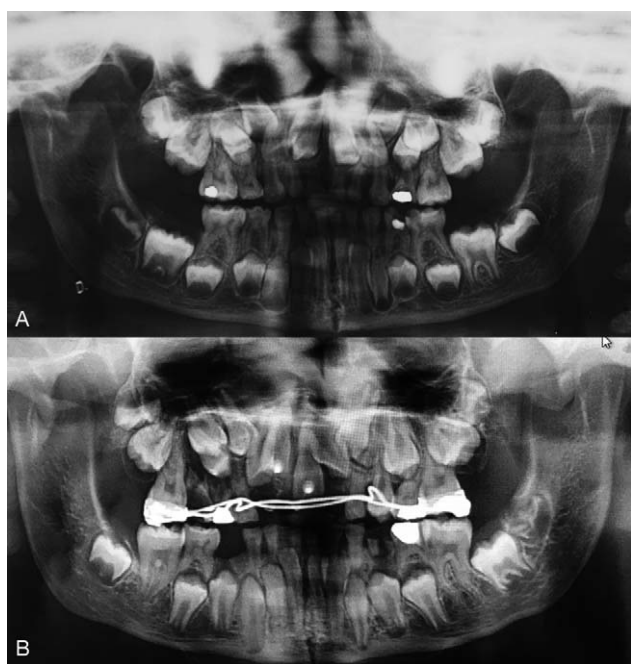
Case 2. (A) First panoramic x-ray showing typical signs of patent symphysis, parallel ramus, pointed and posteriorly directed coronoid processes. (B) Panoramic x-ray during orthodontic treatment (age 12).
